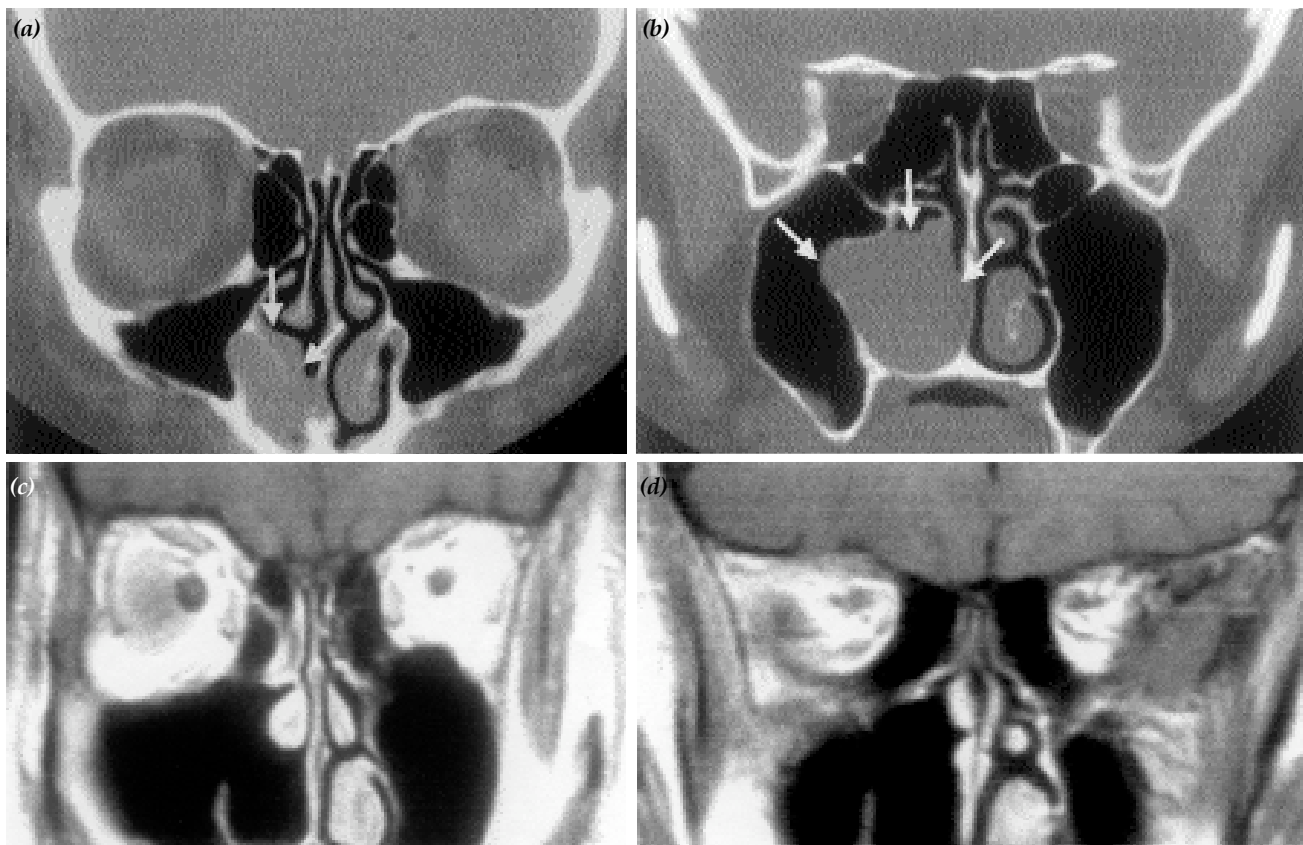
(a, b) Native coronal computed tomography demonstrating a tumoral mass in the right nasal cavity arising from the inferior turbinate and causing an excursion of the medial maxillary sinus wall and a distinct bony destruction (arrows). (c, d) Coronal magnetic resonance imaging two years after endonasal tumor resection indicates no evidence for recurrence of nasal leiomyosarcoma.
